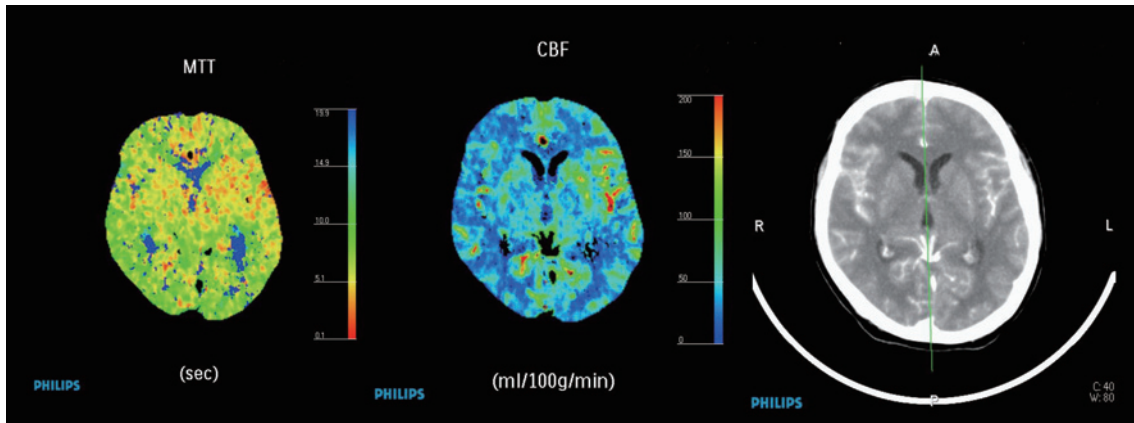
Case4. Perfusion CT performed 1 hour after rupture of the right MCA aneurysm. [left, mean transit time (MTT); middle, cerebral blood flow (CBF); right, plain CT image]. The CBF is significantly reduced and MTT is extended compared with the opposite hemisphere.
